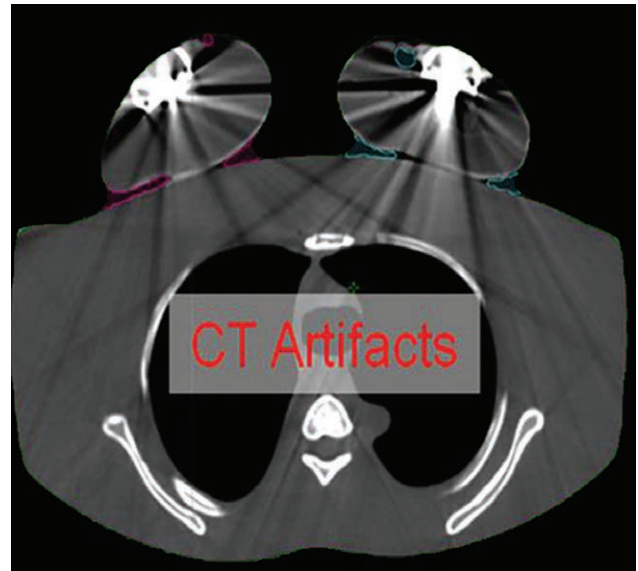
Abundant CT artifact caused by proton beam interaction with the high-Z metal ports of the TE.
